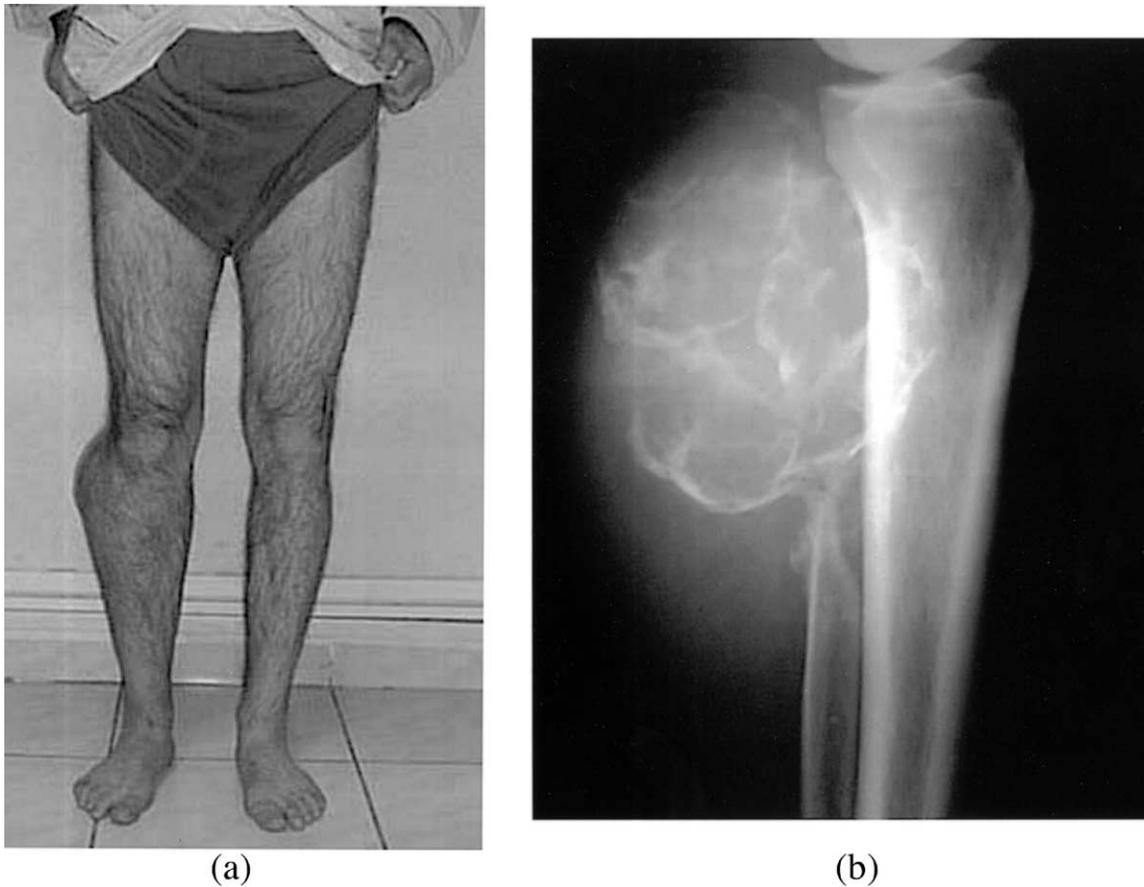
(a) Clinical appearance of the patient who had recurrent GCT. Large soft tissue swelling is visible in the posterolateral compartment of the leg (Case I). (b) Lateral X-ray of the lesion revealed that tumor destructed bony structure and expanded in to soft tissue (Case I).
